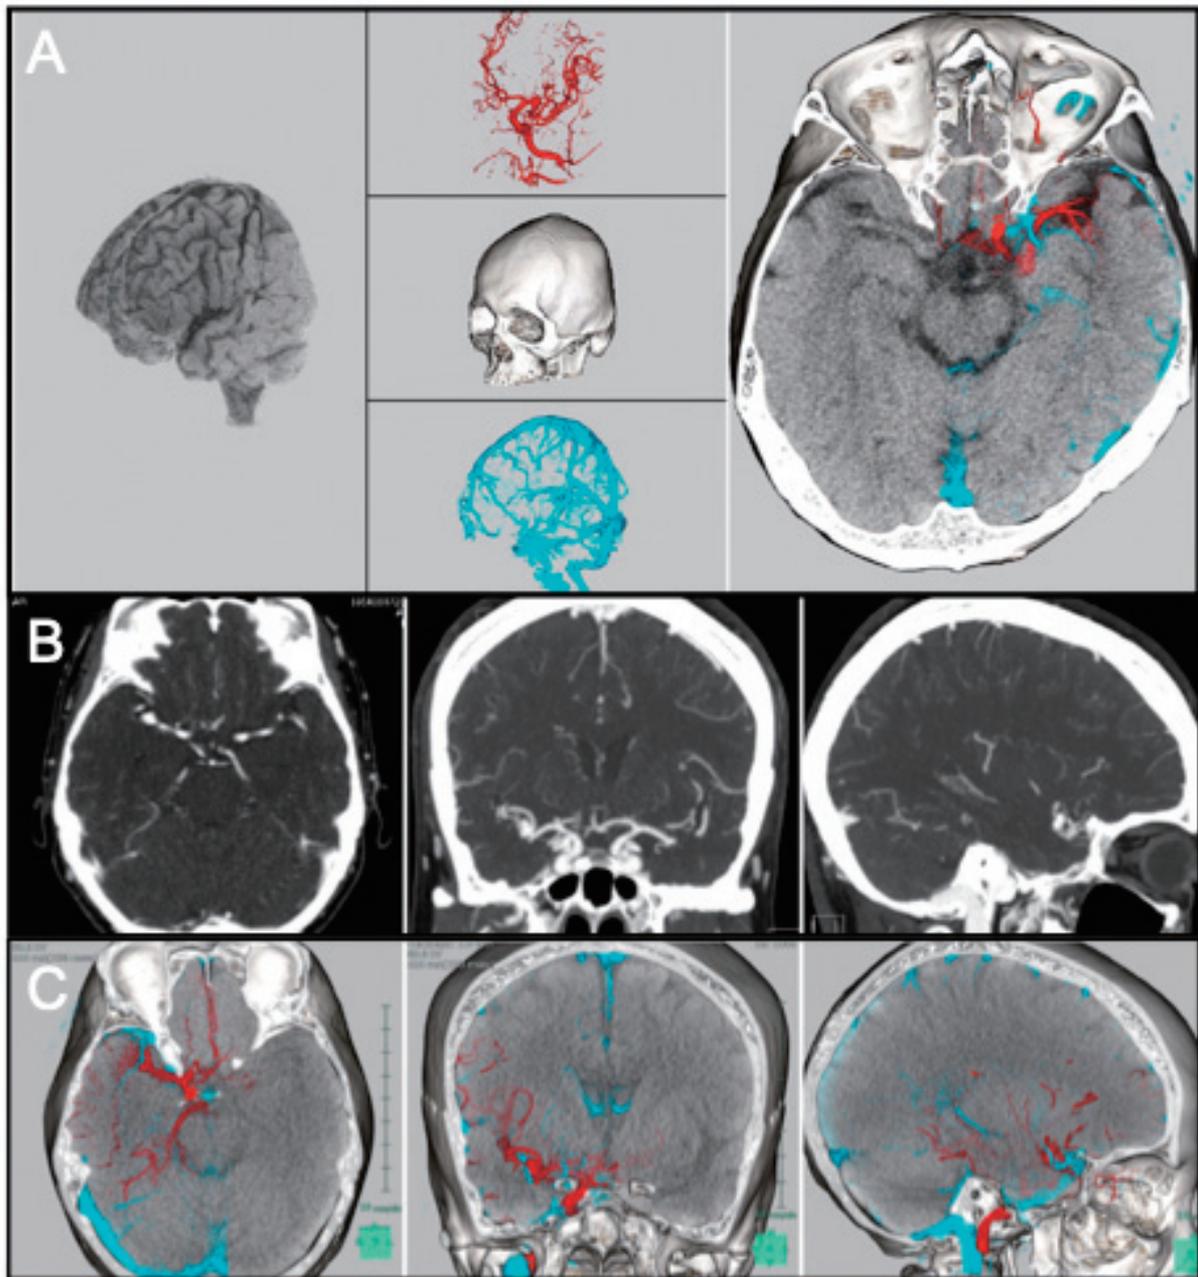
Technical steps for multimodal image fusion (A) and image analysis of deep Sylvian veins (B and C). A: Three-dimensional brain and skull bone depicted by plain CT imaging, and high-resolution arterial and venous images depicted using three-dimensional rotational angiography and CT angiography with venography were used for the reconstruction of the fusion image on a computer workstation (A). B and C: Each construct of the four veins was carefully assessed in the three directions of each image concerning the interrelationship among the brain, blood vessels, and bones using computed tomography venography (B) and multimodal fusion imaging (C).
